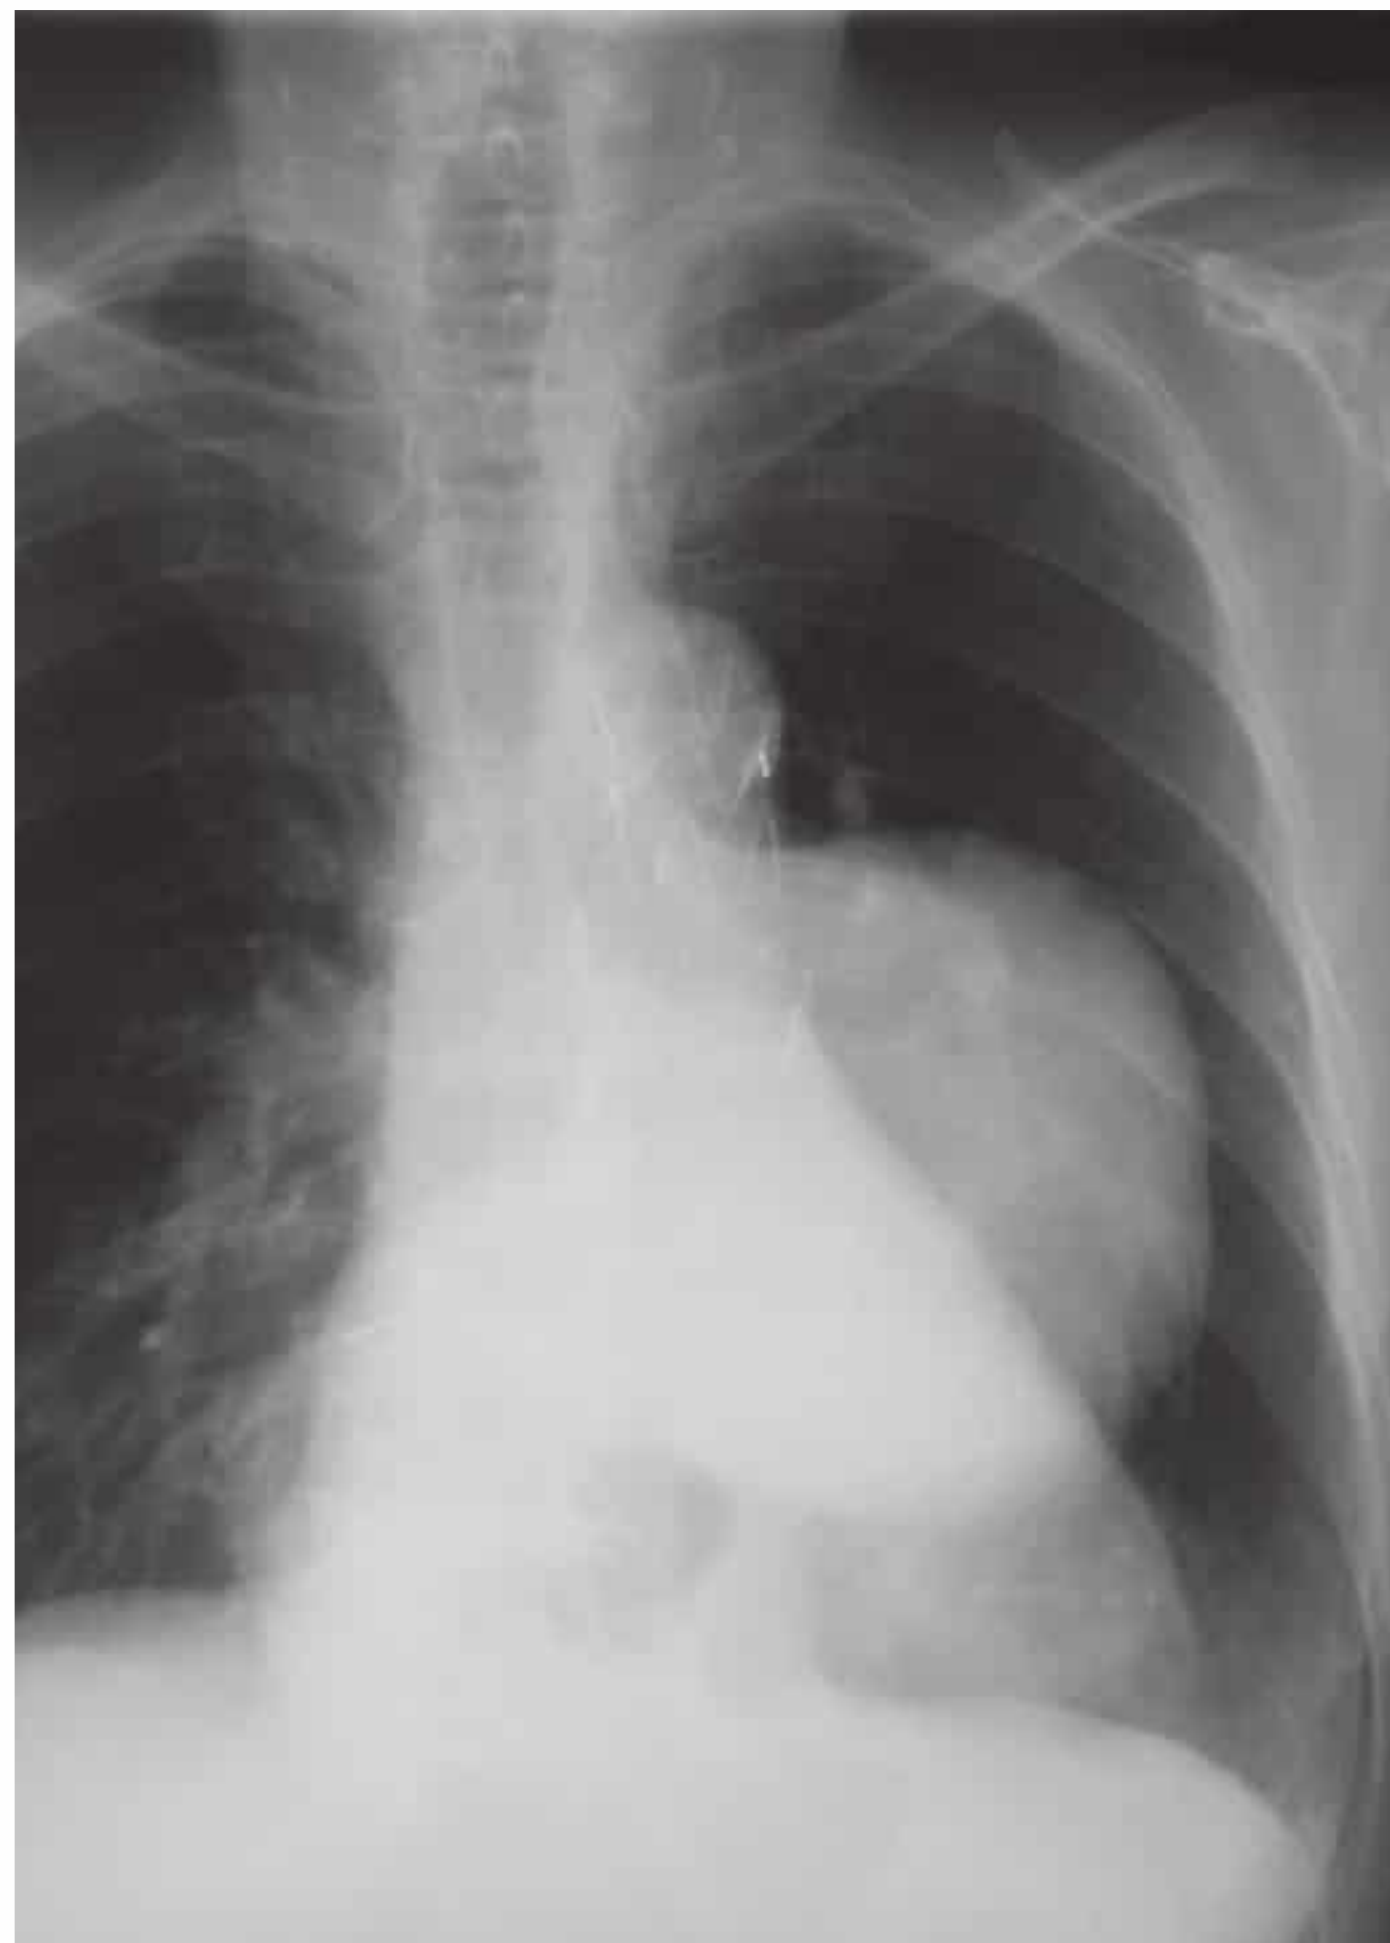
PA chest radiograph of a large thoracic aortic aneurysm, which was successfully managed by the previous insertion of an endovascular stent graft.
